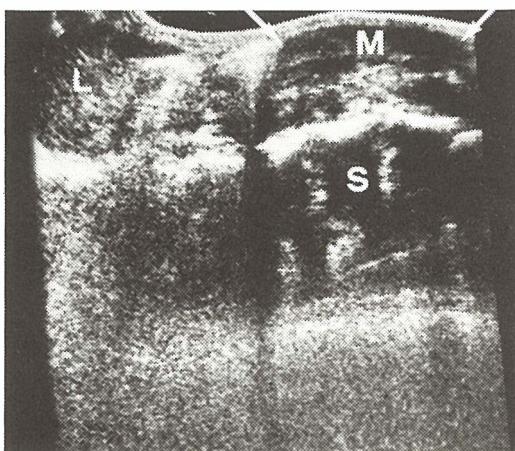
Real – Time ultrasound: longitudinal scan at mid-abdomen demonstrating mixed echogeneity mass (M) extending from the liver (L) to the pelvis. The mass is anterior to the spine (S).
